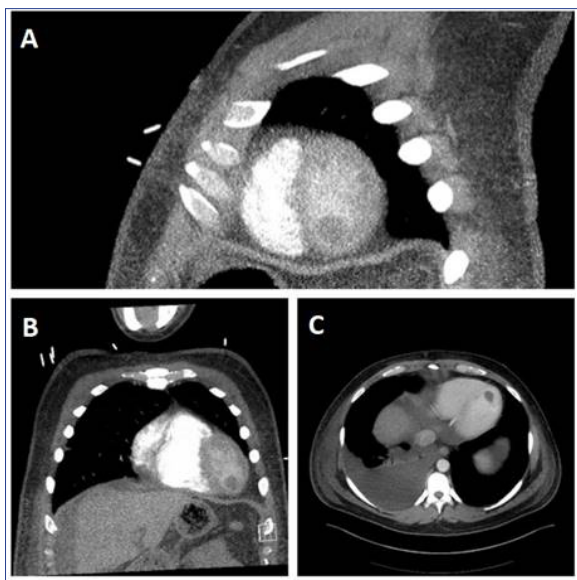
Contrast CT Scan of the Chest: A 2.4 cm opacity can be seen within the apex of the left ventricle (LV) consistent with thrombus formation. The LV thrombus can be seen in the sagittal (A), coronal (B) and axial (C) views
